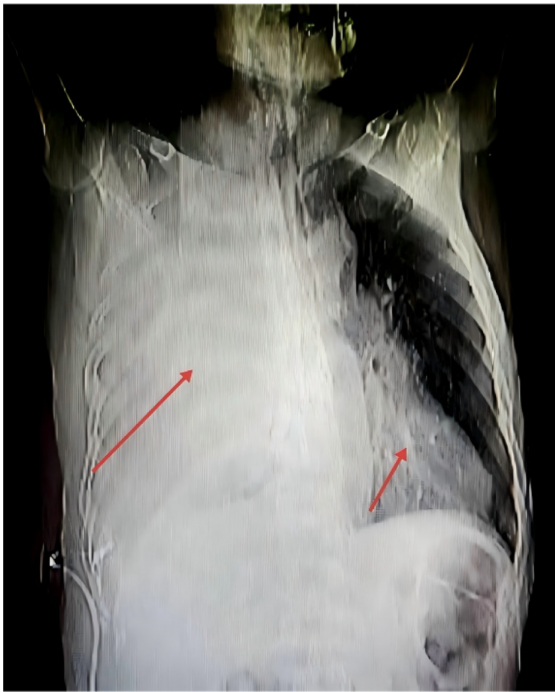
Patient's routine chest radiography examination. The right lung and right lower part of the left lung appear to be affected by the tumor. The affected areas have been marked with arrows.
